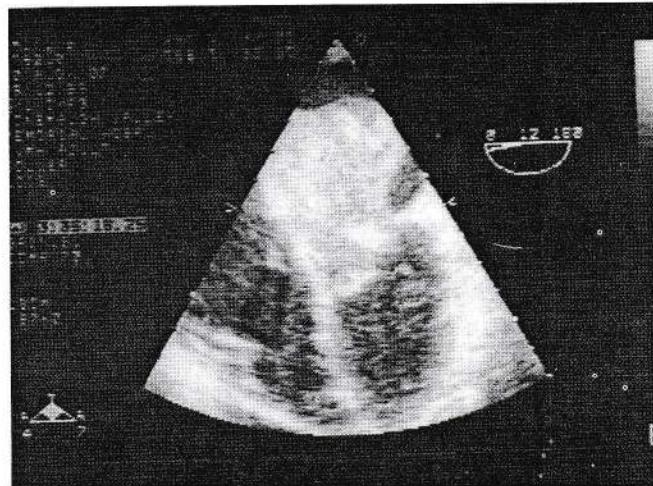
Transesophageal Echocardiography (TEE) demonstrating left atrium is practically occupied by a giant myxoma protruding into the left ventricle via mitral valve almost completely obstructing left atrial outflow in diastole.
